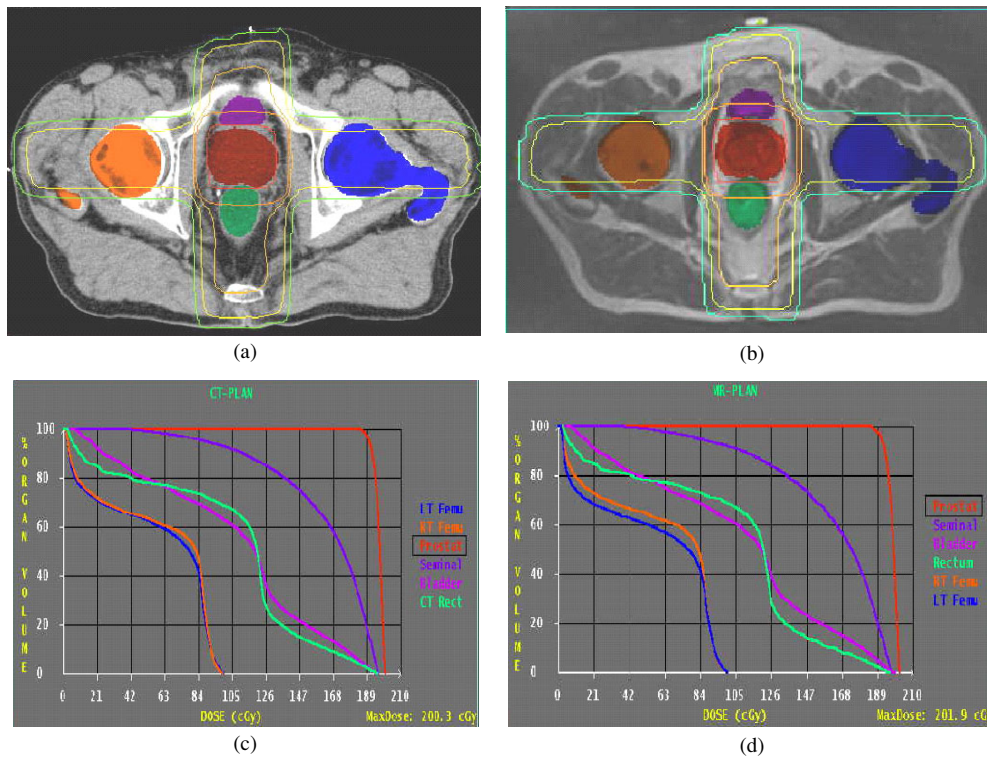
Comparison of isodose distributions based on CT (a) and MRI (b) and their corresponding DVHs for the PTV and critical structures based on CT (c) and MRI (d). The isodose lines represent 95%, 70%, 60%, 40% and 20% of the prescribed target dose.
